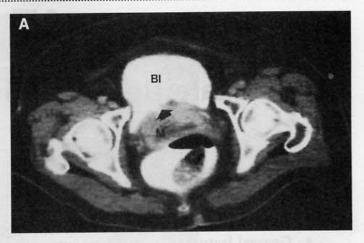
(A) CT scan showing invasive cervical carcinoma. Note that the posterior margin of the contrast-filled urinary bladder (BI) is compressed because of the tumor mass (M) of the cervical carcinoma. (B) Radiograph of a calcified uterine fibrinoid (leiomyoma). Fibrinoids appear as nodules with a whorled pattern and often are calcified. A very large fibrinoid may occupy the entire pelvic cavity or may even extend into the abdomen. [A reprinted with permission from Gross BH, Callen PW: Ultrasound in the uterus. In Callen PW (ed): Ultrasonography in Obstetrics and Gynecology. Philadelphia, WB Saunders, 1983; B reprinted with permission from Eisenberg RL: Gastrointestinal Radiology: A Pattern Approach. Philadelphia, JB Lippincott, 1983.]
